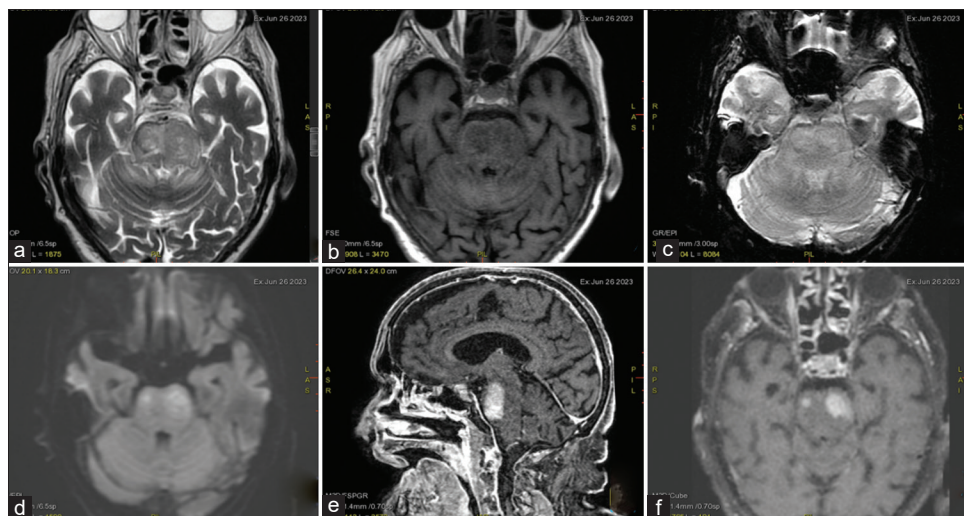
Areas of parenchymal swelling with signal change appearing hyperintense on T2 (a), hypointense on T1 (b) showing intense enhancement in both halves of pons on post contrast T1W Sagittal and axial images(d,e). Some of these areas show slight restricted diffusion and rest show facilitated diffusion on DWI (d). No haemorrhage on GRE(c) in these areas
